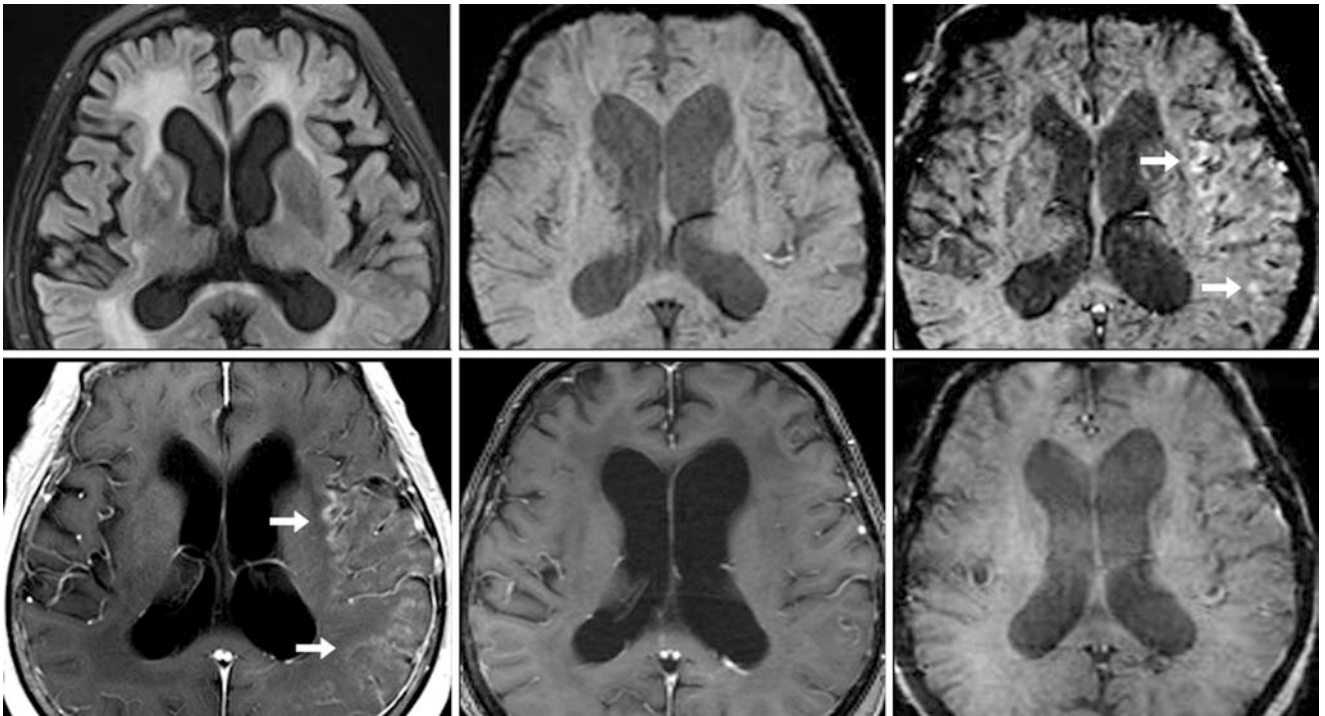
A 68 year old with SMART syndrome (stroke-like migraine attacks after radiation therapy). Fifteen years after cranial radiation for a grade 2 astrocytoma, the patient presented with severe headaches who had since had yearly MRIs that were negative for recurrence. A non-contrast 3T FLAIR MRI (*top left*) showed postradiation findings, while
